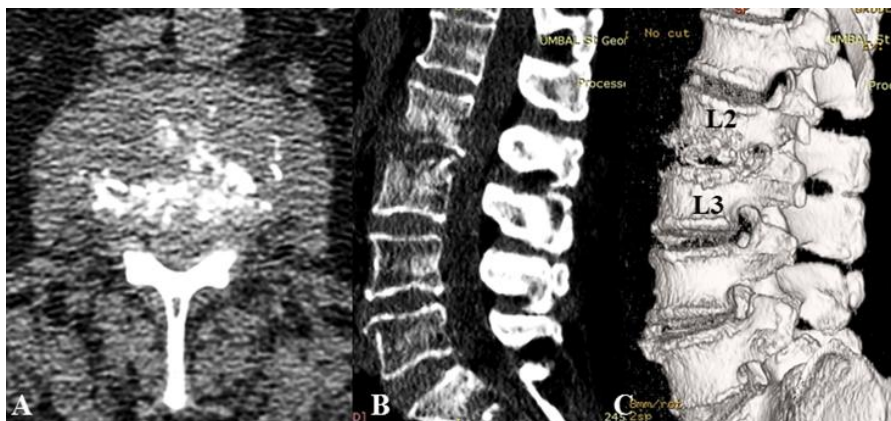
CT images of spondylodiscitis at L₂–L₃ level:
